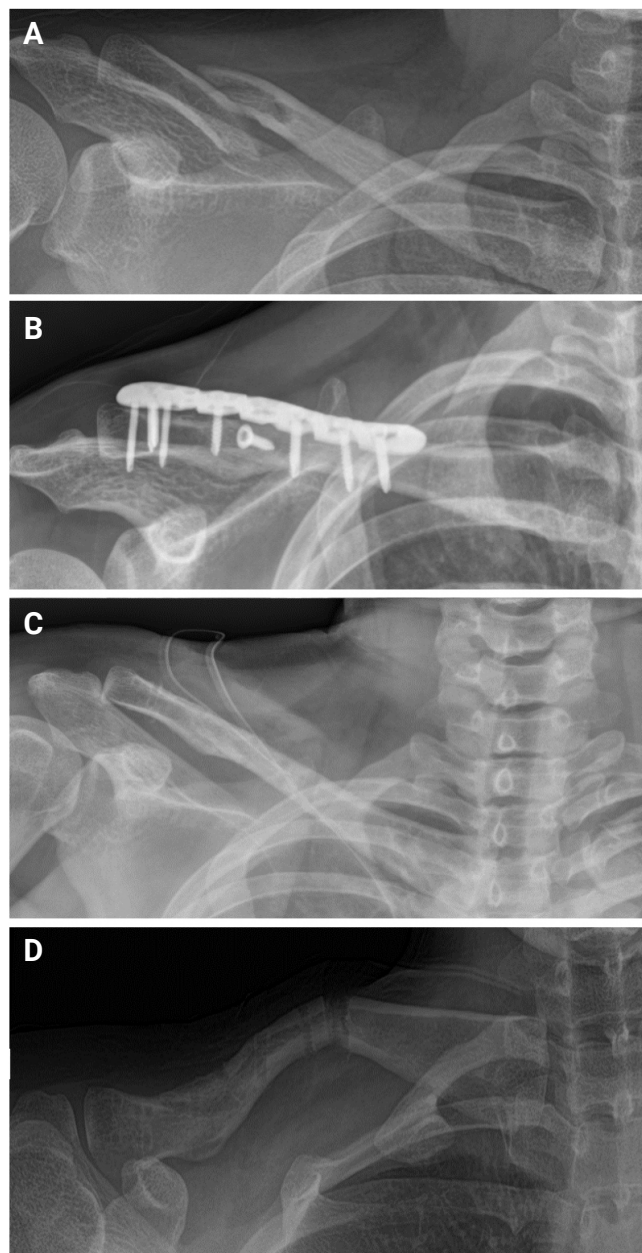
A 22-year-old woman with a right-sided displaced mid-shaft clavicle fracture underwent plate fixation. (A) The preoperative radiograph shows a midclavicular fracture (Robinson 2B1). (B) A radiograph at 1 year postoperative shows successful union of the fracture with the implanted plate and screw. (C) After implant removal, the radiograph shows achieved union. (D) A radiograph obtained 4 weeks after hardware removal shows a new onset fracture at a different site due to hardware removal.
